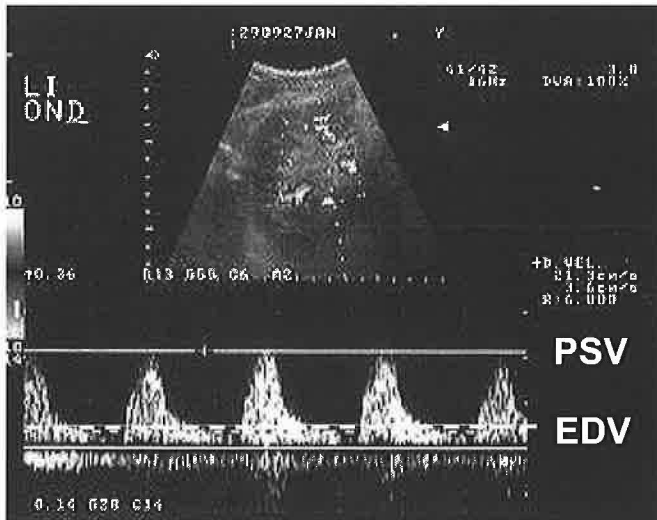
Duplex ultrasonography in a 70-year-old hypertensive patient with less than 50% luminal narrowing of the left renal artery stenosis. The resistance index (RI) is increased in both the upper and lower pole arteries, indicative of renal parenchymal disease, likely to be from long standing hypertension.
